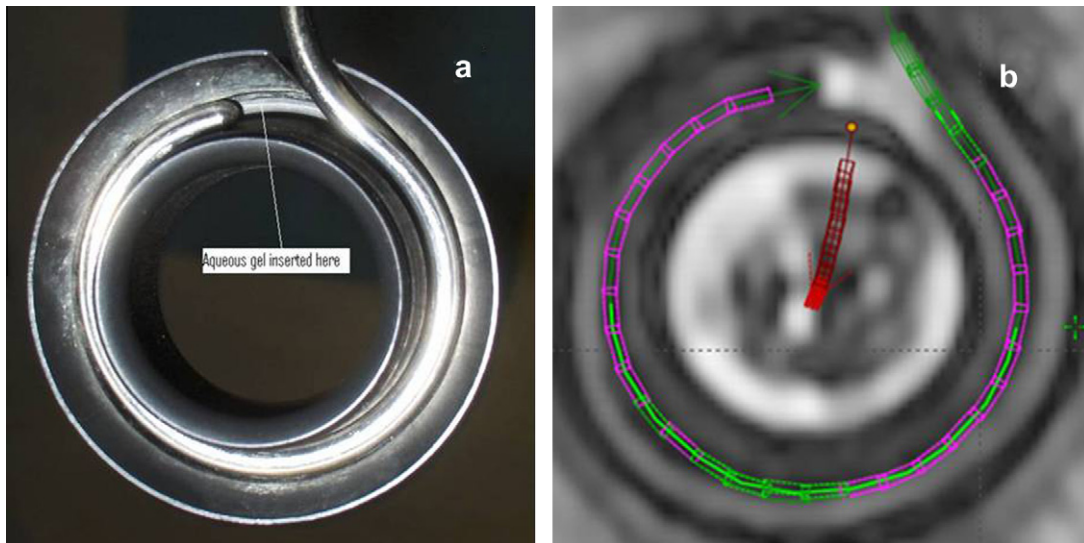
Reconstruction of titanium ring applicator in MR images. (a) Placement of aqueous gel at the end of the ring channel before assembly of the ring cap. (b) Rotation of the reconstructed ring according to the position of the signal from the aqueous gel.
